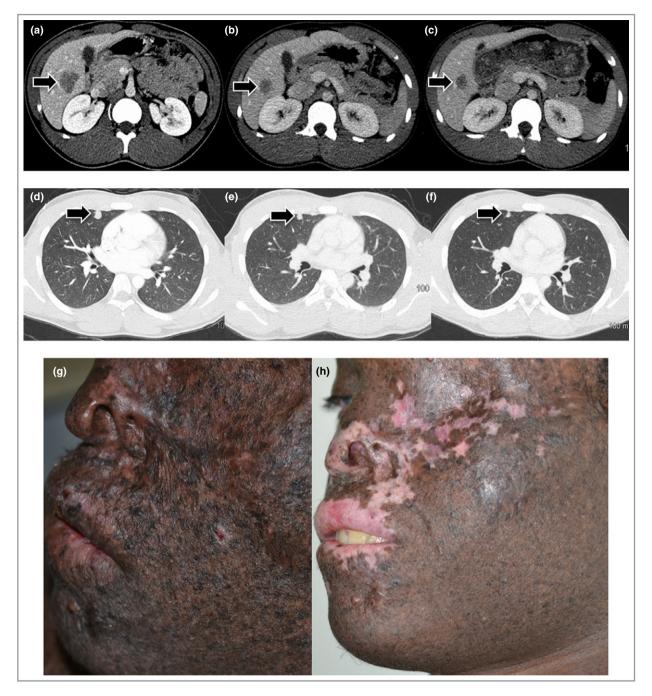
Evolution of metastases and clinical response to treatment. (a) Axial computed tomography (CT) scan with contrast shows the hepatic metastases before treatment measuring 22×30 mm (arrow); (b) and (c) after treatment with a programmed cell death-1 (PD-1) inhibitor: axial CT with contrast shows the reduction of the metastases consistent with treatment response after four cycles (b) measuring 17×24 mm (arrow) and after eight cycles (c) measuring 13×22 mm (arrow); (d) axial CT shows one of the pulmonary metastases before treatment measuring 11×11 mm (arrow); (e) and (f) axial CT shows response of the pulmonary metastases after four cycles (e) measuring 6.5×8 mm (arrow) and after eight cycles (f) measuring 5.5×7.5 mm. (g) Shows skin before treatment and (h) shows the clinical response to treatment after eight cycles with disappearance of cancerous and precancerous lesions, vitiligoid depigmentation.
